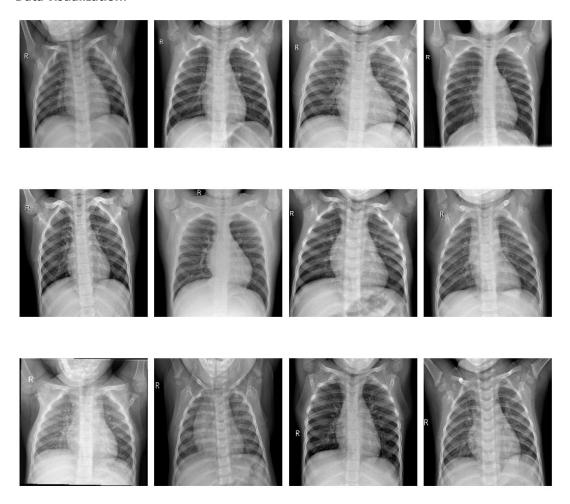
Normal x-ray images of the dataset
